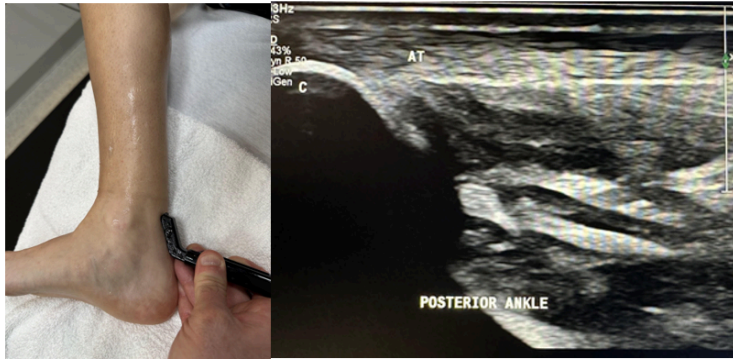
Side-by-side pictures of the transducer position and posterior ankle sagittal view of the Achilles tendon (AT) insertion into the calcaneus (C). The abbreviations given here and labeled on the ultrasound image represent the corresponding structures.
